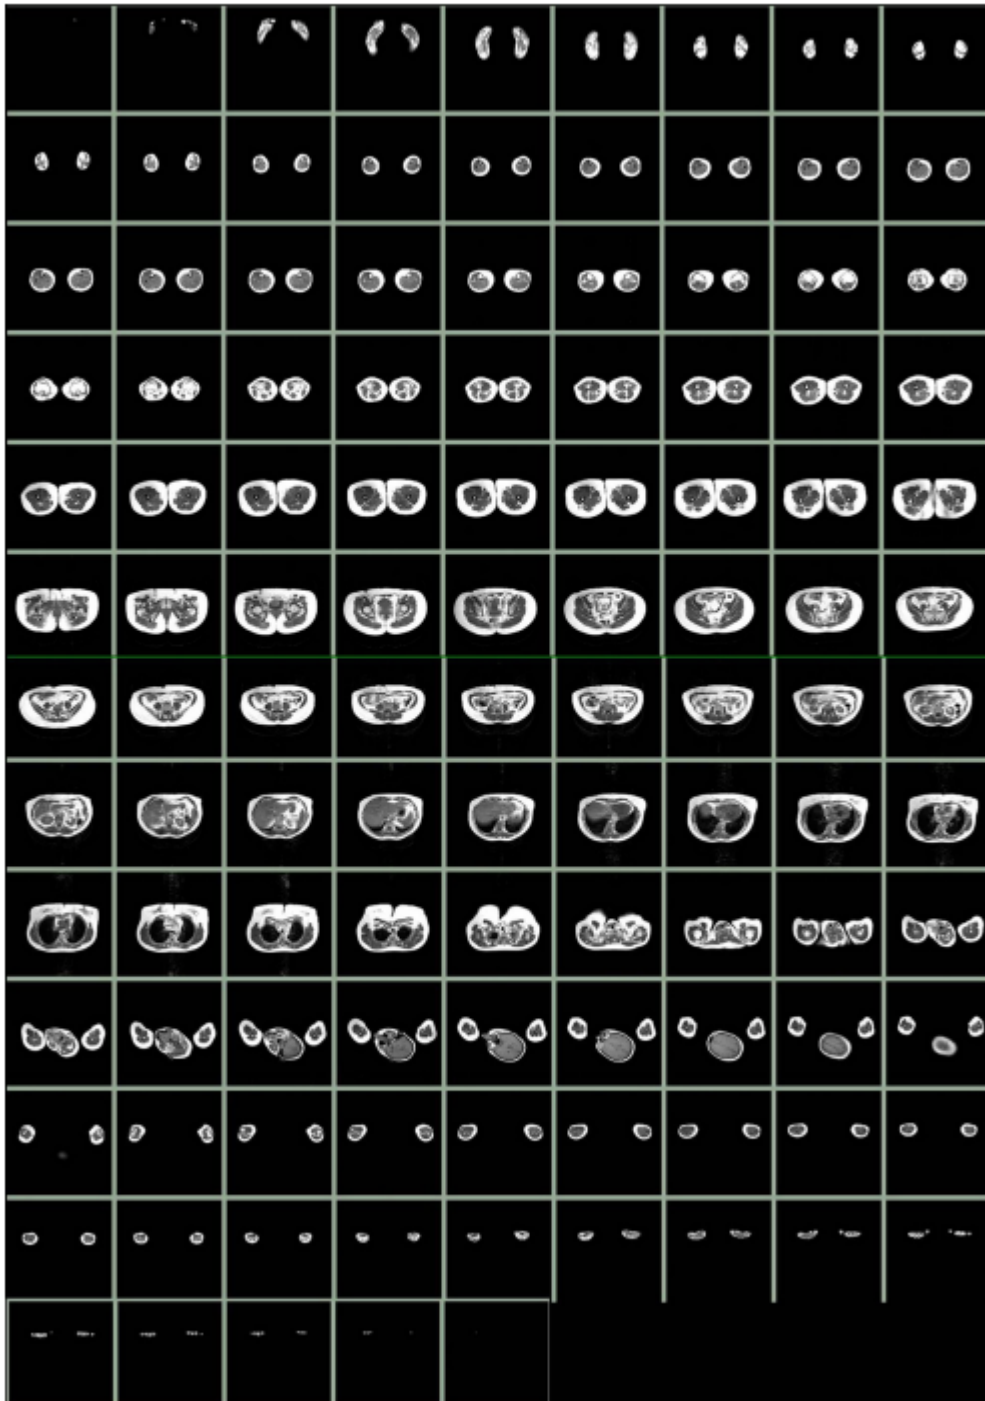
Whole body MRI dataset from a healthy volunteer obtained at 1.5T. Fat appears as high intensity signal (white).
